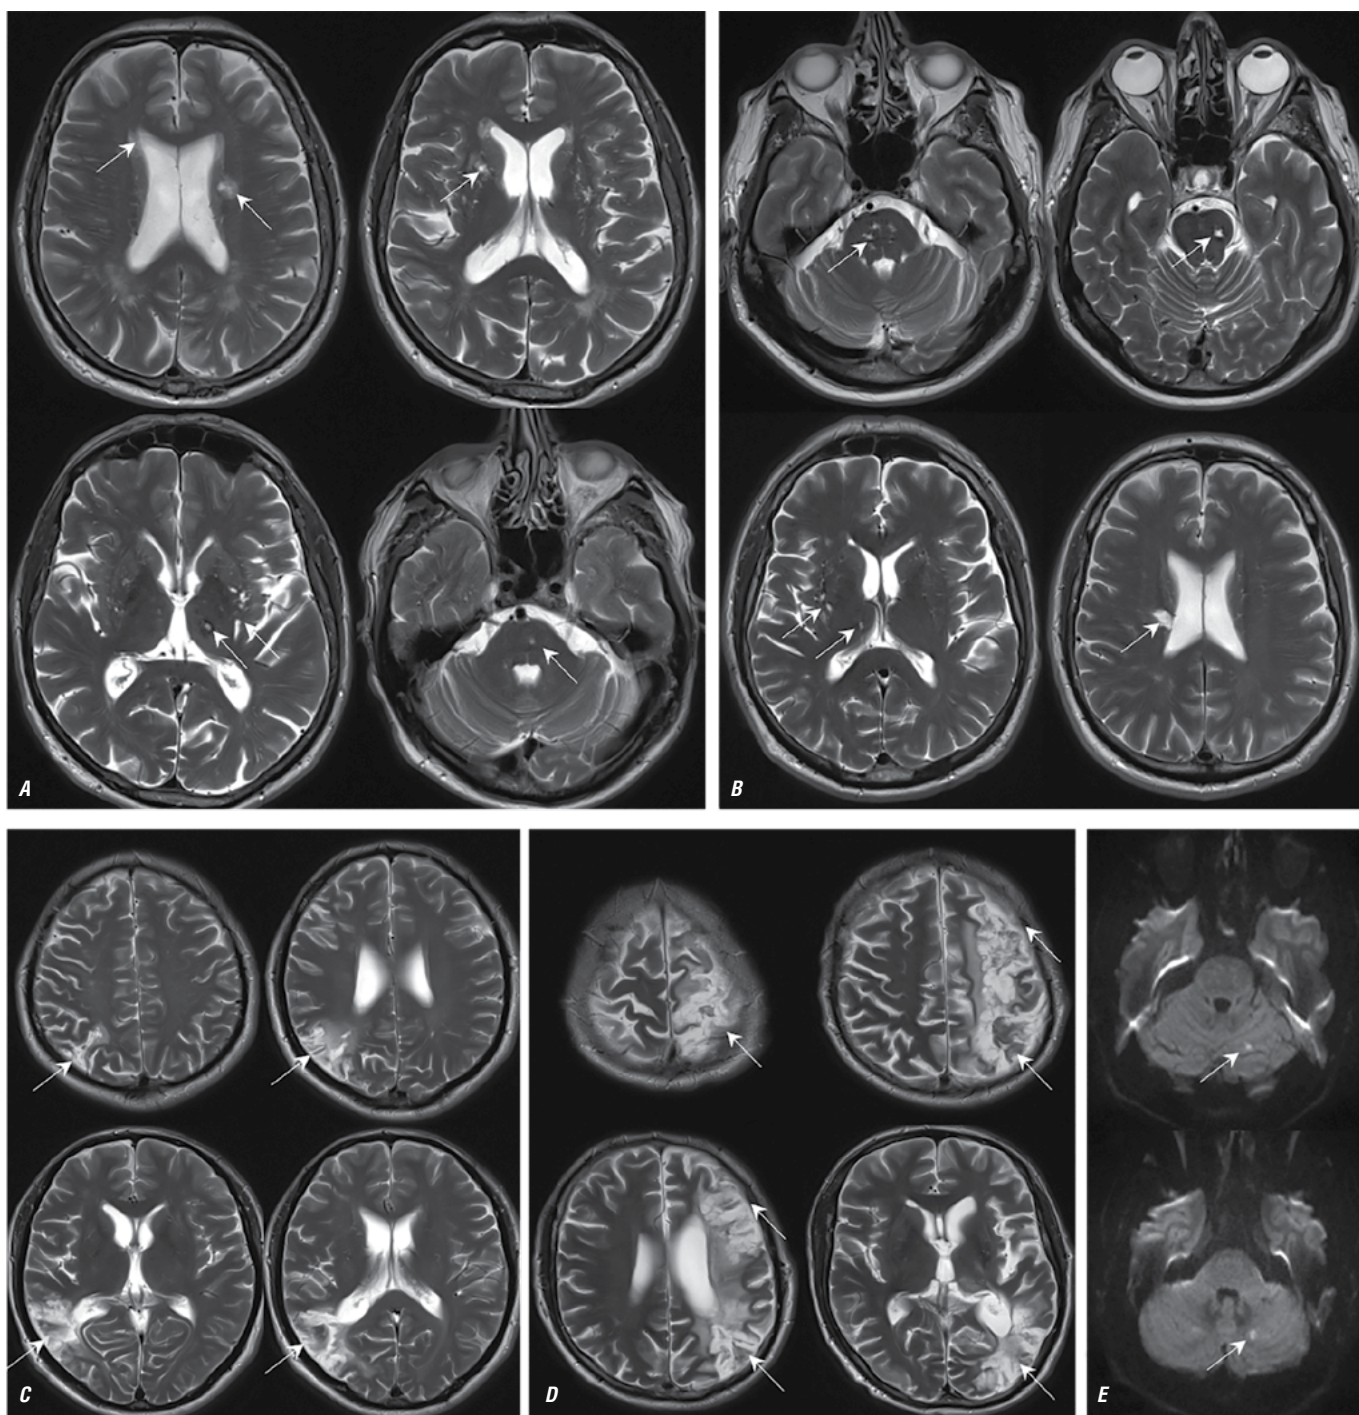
Brain MRI of patients with PV in axial T2 (A–D) and DWI sequences with a b-value of 1,000 s/mm² (E). Two main involvement patterns are visualized: small post-infarction lesions in the deep white matter, basal ganglia, and brainstem (A, B); one patient had lesions of acute ischemia in the left cerebellar hemisphere (E); large cortical post-infarction changes in the middle cerebral artery system and adjacent perfusion territories without basal ganglia involvement (C, D); post-infarction changes (A–D) and acute ischemic lesions (E) are indicated by arrows.
